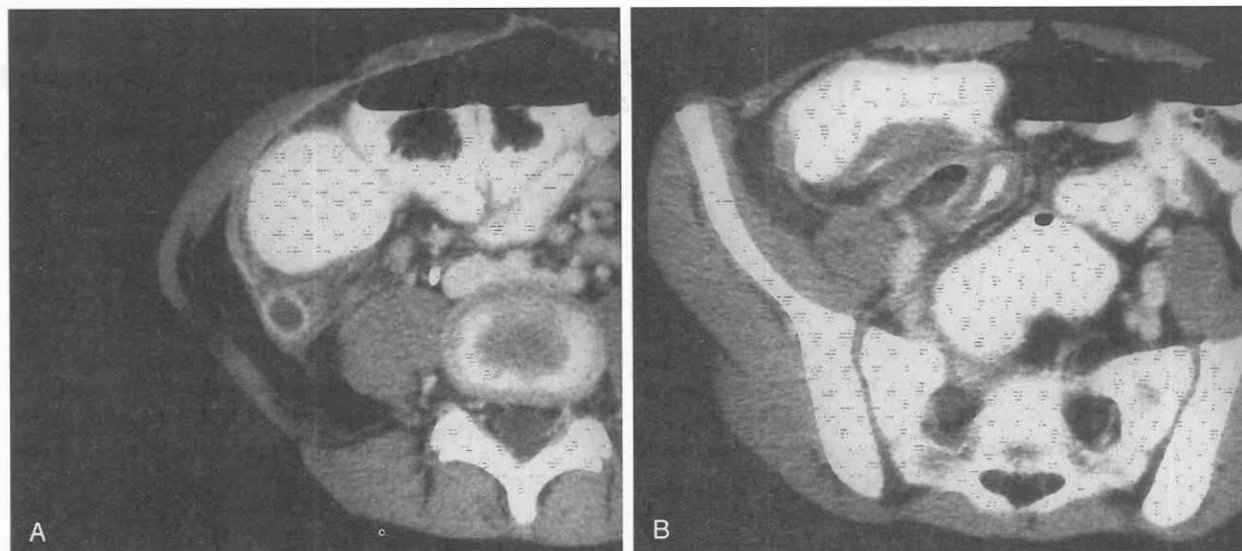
Acute appendicitis. A, CT scan through the lower abdomen in a patient with appendicitis demonstrates an enlarged, thick-walled appendix with wall enhancement and an associated infiltration of surrounding fat. B, CT scan through the upper pelvis in the same patient demonstrates cecal apical thickening.
